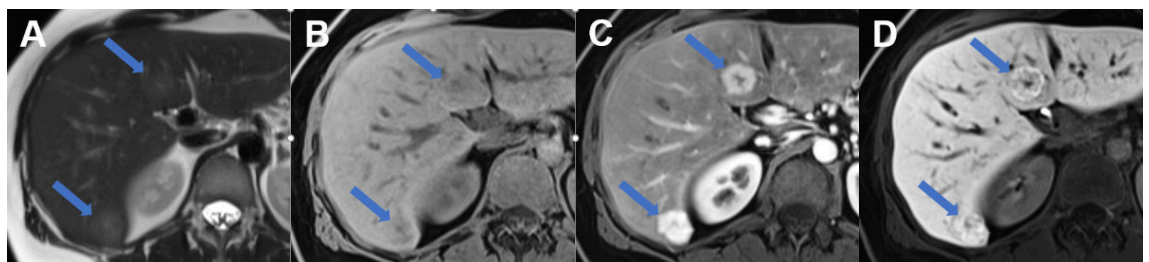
Focal nodular hyperplasia on MRI. MRI of focal nodular hyperplasia in liver segment VI und IVb (arrows) with A slight hyperintense signal on T2w image with hyperintense central scar, B slight hypointense signal on T1w image with hypointense central scar, C avid arterial enhancement and D increased metabolisation of the hepatobiliary contrast agent during the hepatobiliary phase.
